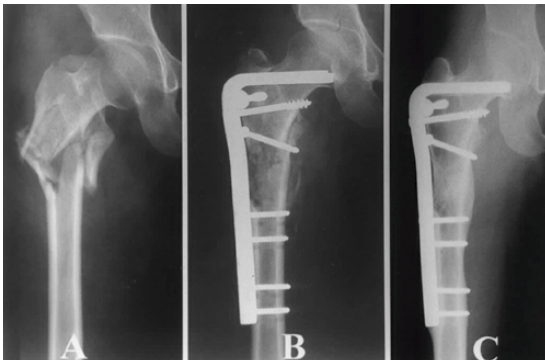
Initial radiograph shows multifragmentary intertrochanteric fracture (AO type A3.3) of the femur in a 22-year-old woman.
